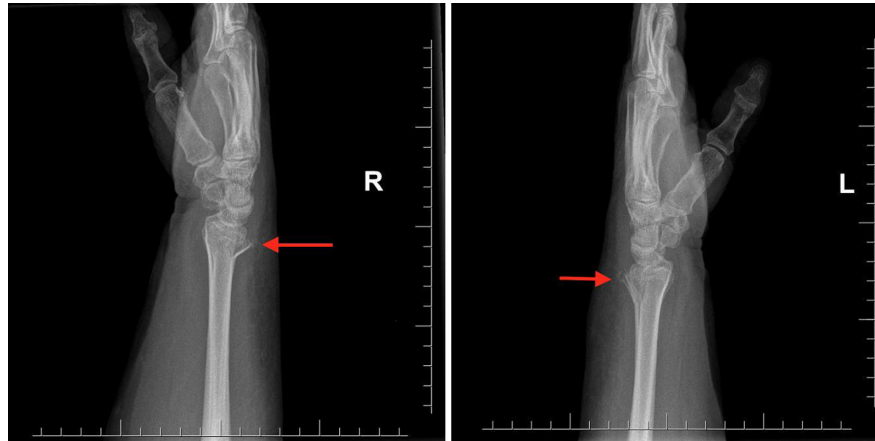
Lateral radiographic images of the right and left distal radius fractures, respectively. Red arrows indicate the dorsal metaphyseal spikes caused by the dorsally displaced distal radius fractures.
